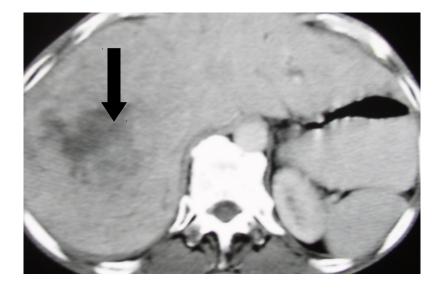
1 CT Scan - Hepatocellular carcinoma
